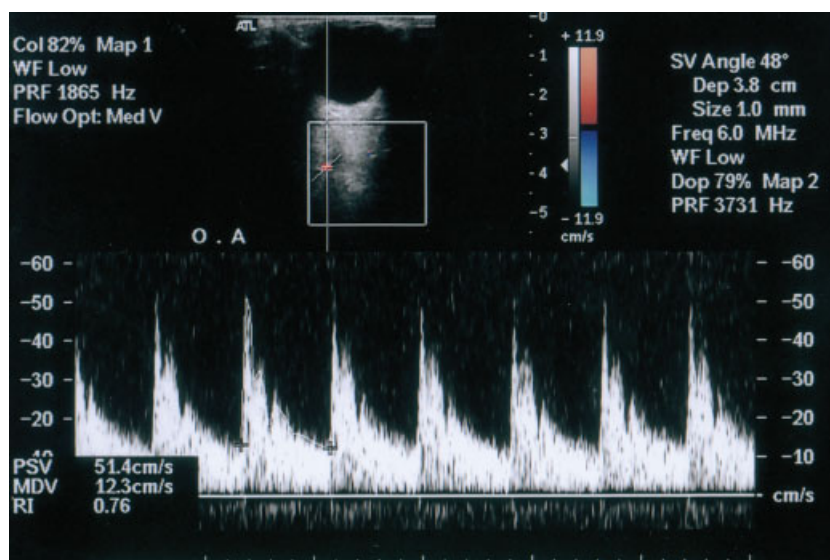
Color duplex sonogram of an ophthalmic artery (OA) in a patient with obstructive sleep apnea syndrome shows a peak systolic velocity (PSV) of 51.4 cm/second and a resistance index (RI) of 0.76.
